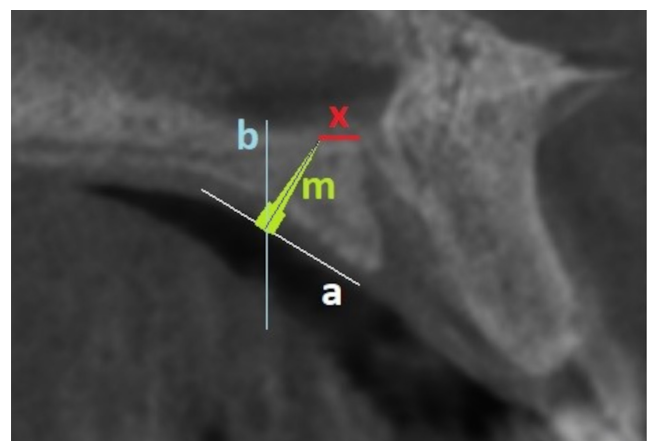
Cone beam computed tomography (CBCT) image of the sagittal plane presenting the midpalatal microimplant placement technique and measuring the distance between the microimplant tip and the nasal opening of the nasopalatine canal
